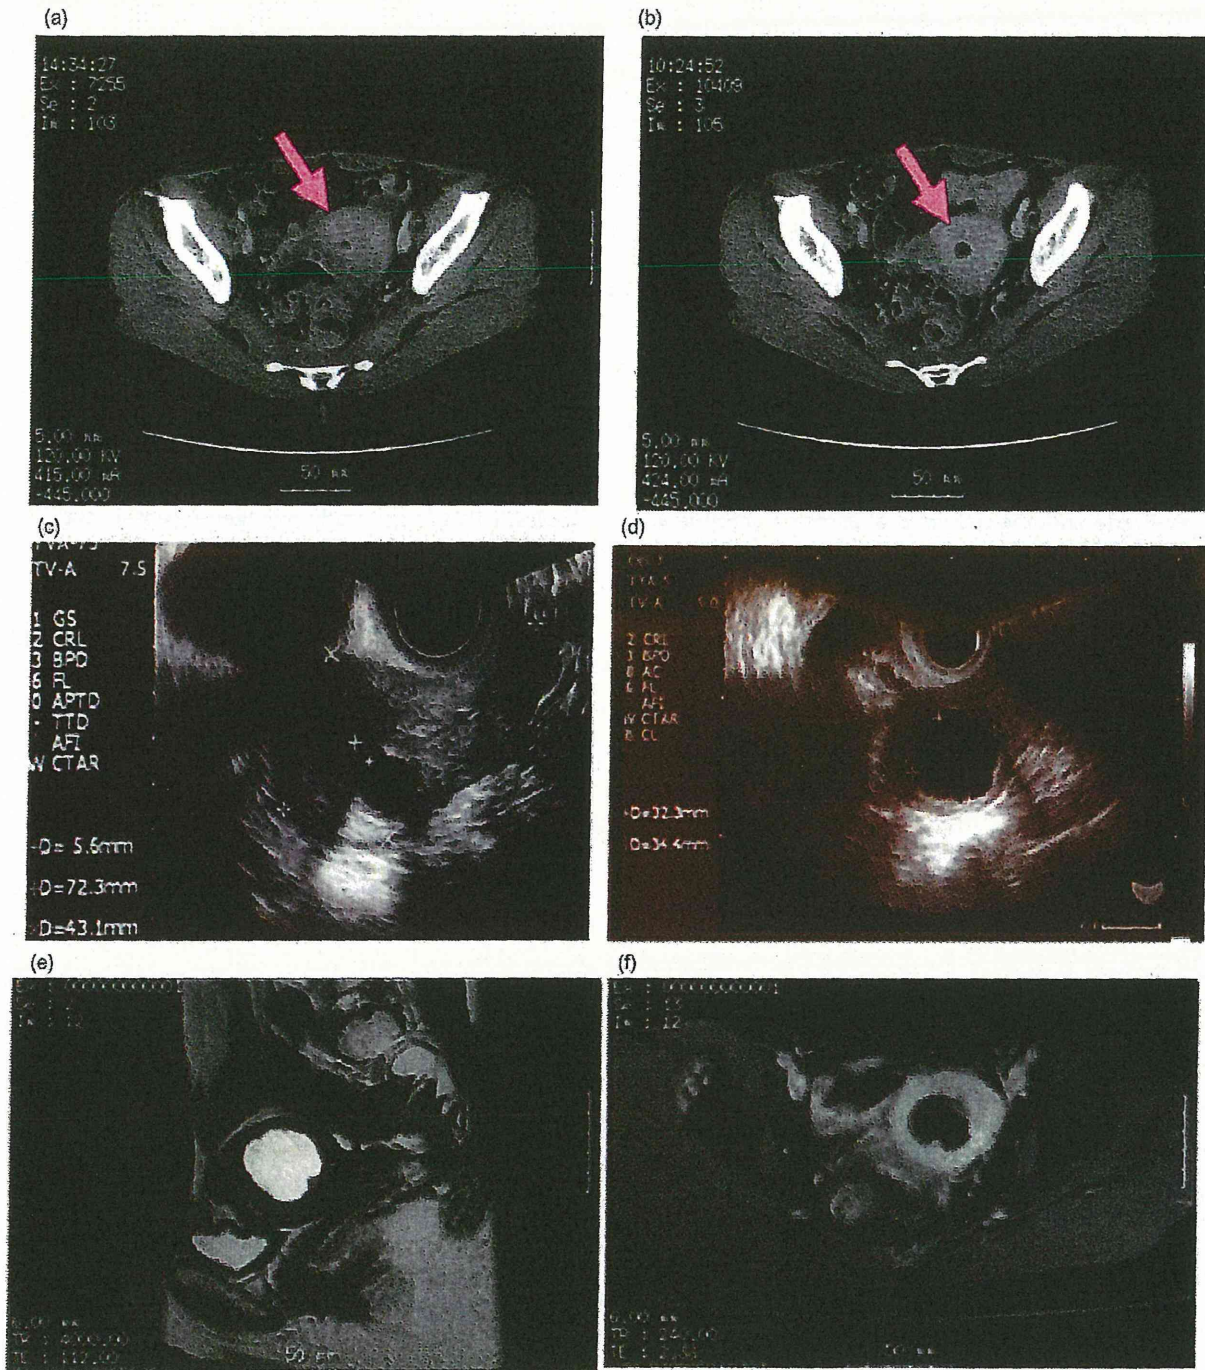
Images of the tumor by (a,b) computed tomography scan, (c,d) transvaginal ultrasonography, and (e,f) magnetic resonance imaging. (a) A cystic mass was first observed in the uterine myometrium 4 months after toremifene treatment in November 2007. (b) The cystic mass was more clearly detected in May 2008. (c) An intramyometrial cystic mass (14 × 16 mm) observed at the patient's first visit. (d) The cystic mass measured 32 × 34 mm 13 months after the first visit. (e) Sagittal T2-weighted image of a cystic tumor 38 mm in diameter located in the posterior myometrium. (f) Gadolinium-enhanced axial T1-weighted image of a homogeneous enhancement of the solid part of the tumor similar to normal myometrium.
